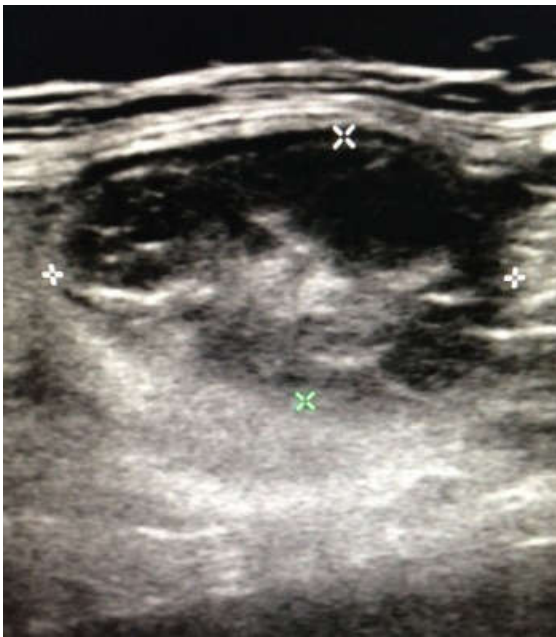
Sonographic View of Ascending Colon Appendagitis
